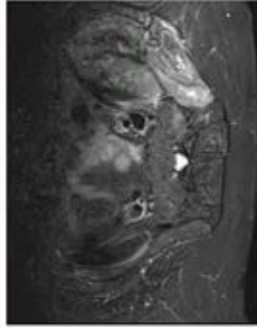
MRI from 10/24/23 further captured the 3.1 cm mass that had overtaken the patient's left hemipelvis
